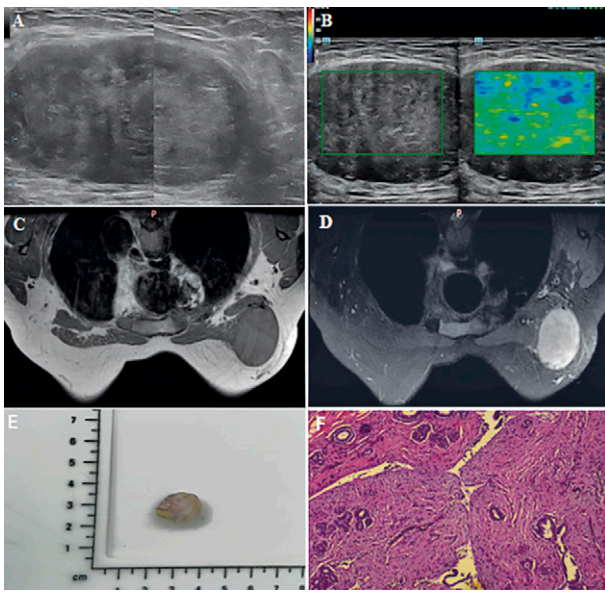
(A) US scan showed regular shape, clear boundaries, smooth edges; (B) Shear wave elastography showed a soft elasticity; (C-D) MRI showed T1W1 low-to-intermediate signal, T2W1 slightly high signal, high signal on diffusion-weighted imaging (DWI), regular morphology, smooth margins, and visible vascular flow voids; (E-F) Pathology showed the tumor borders are locally unclear, the fibrous interstitium has a certain heterogeneity, and the leaf-like structure can be seen in the foci.
